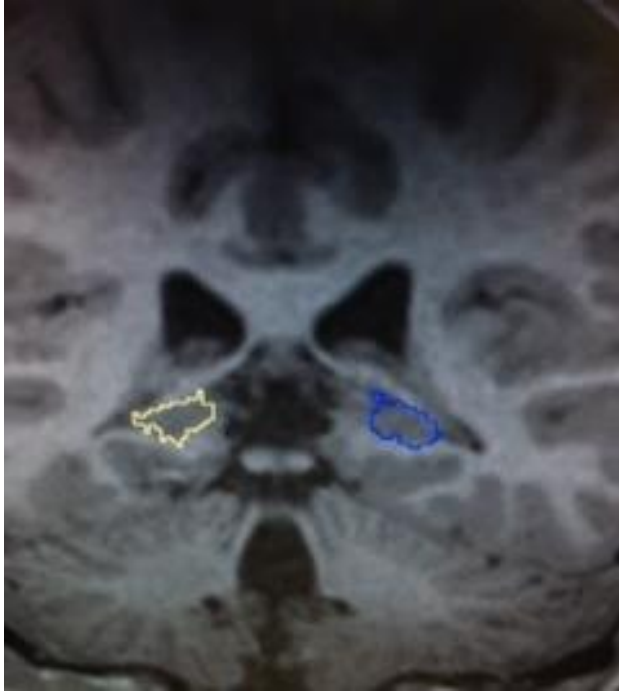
Disappearance of pulvinar with tracing; first slice right/left posterior hippocampus; MRI scan; coronal view
